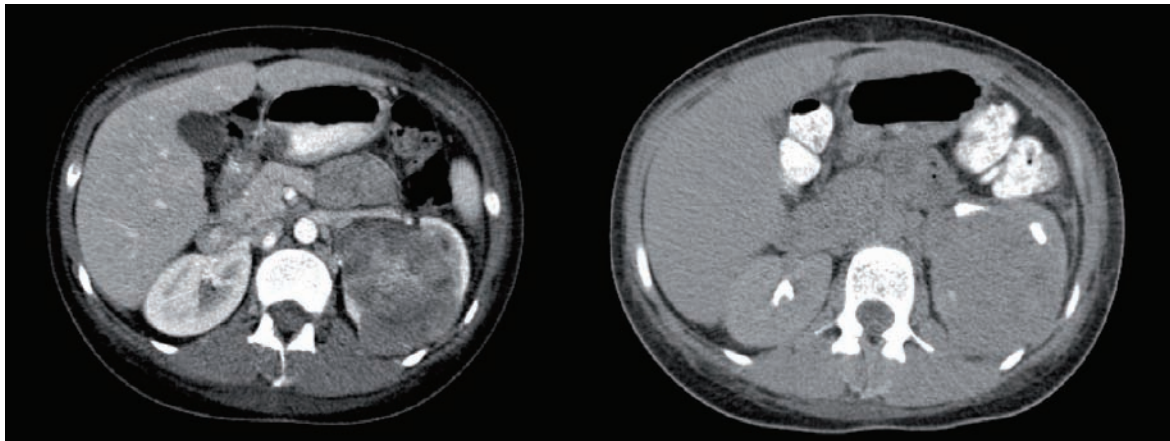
Computed tomography images of solid mass in the left kidney.
